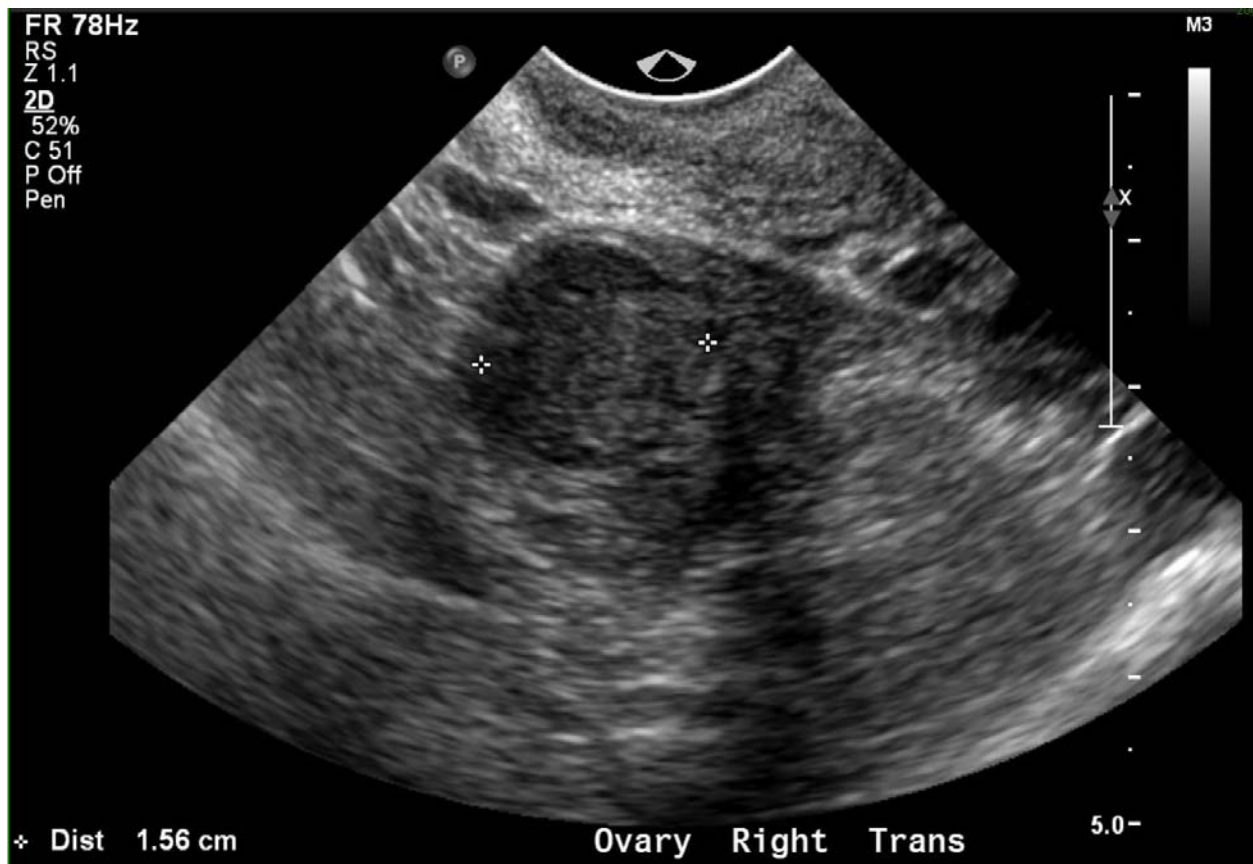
Endovaginal transverse grayscale ultrasound image of the homogeneously echogenic, solid mass in the right ovary, which measures 2.3 x 1.5 x 1.6 cm (between calipers) and does not enlarge the right ovary or alter its external contour.
